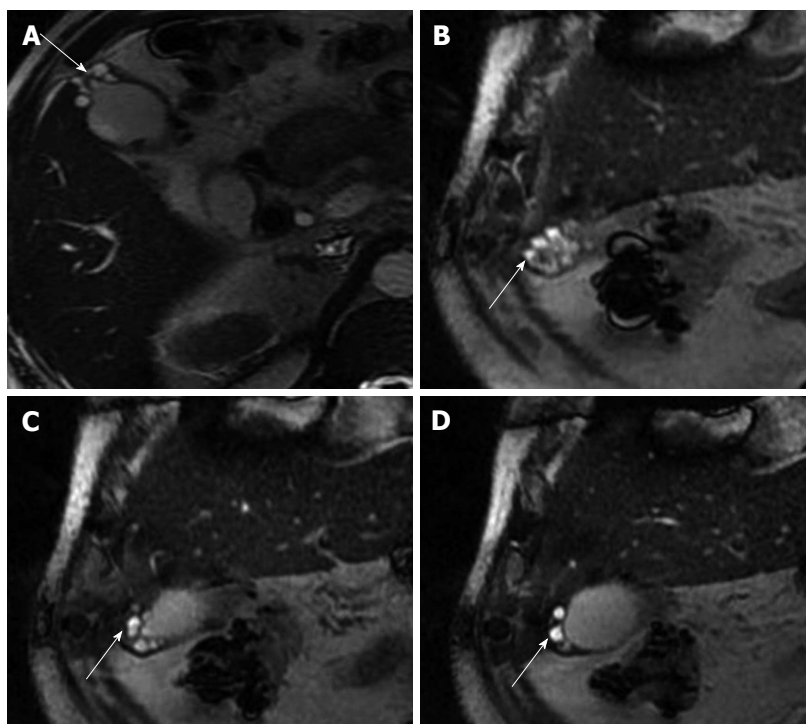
Axial (A) and coronal (B-D) T2W magnetic resonance images showing multiple curvilinearly arranged hyperintense intramural cavities (arrows) in gallbladder fundal region ("pearl necklace" appearance) - a characteristic feature of gallbladder adenomyomatosis.
